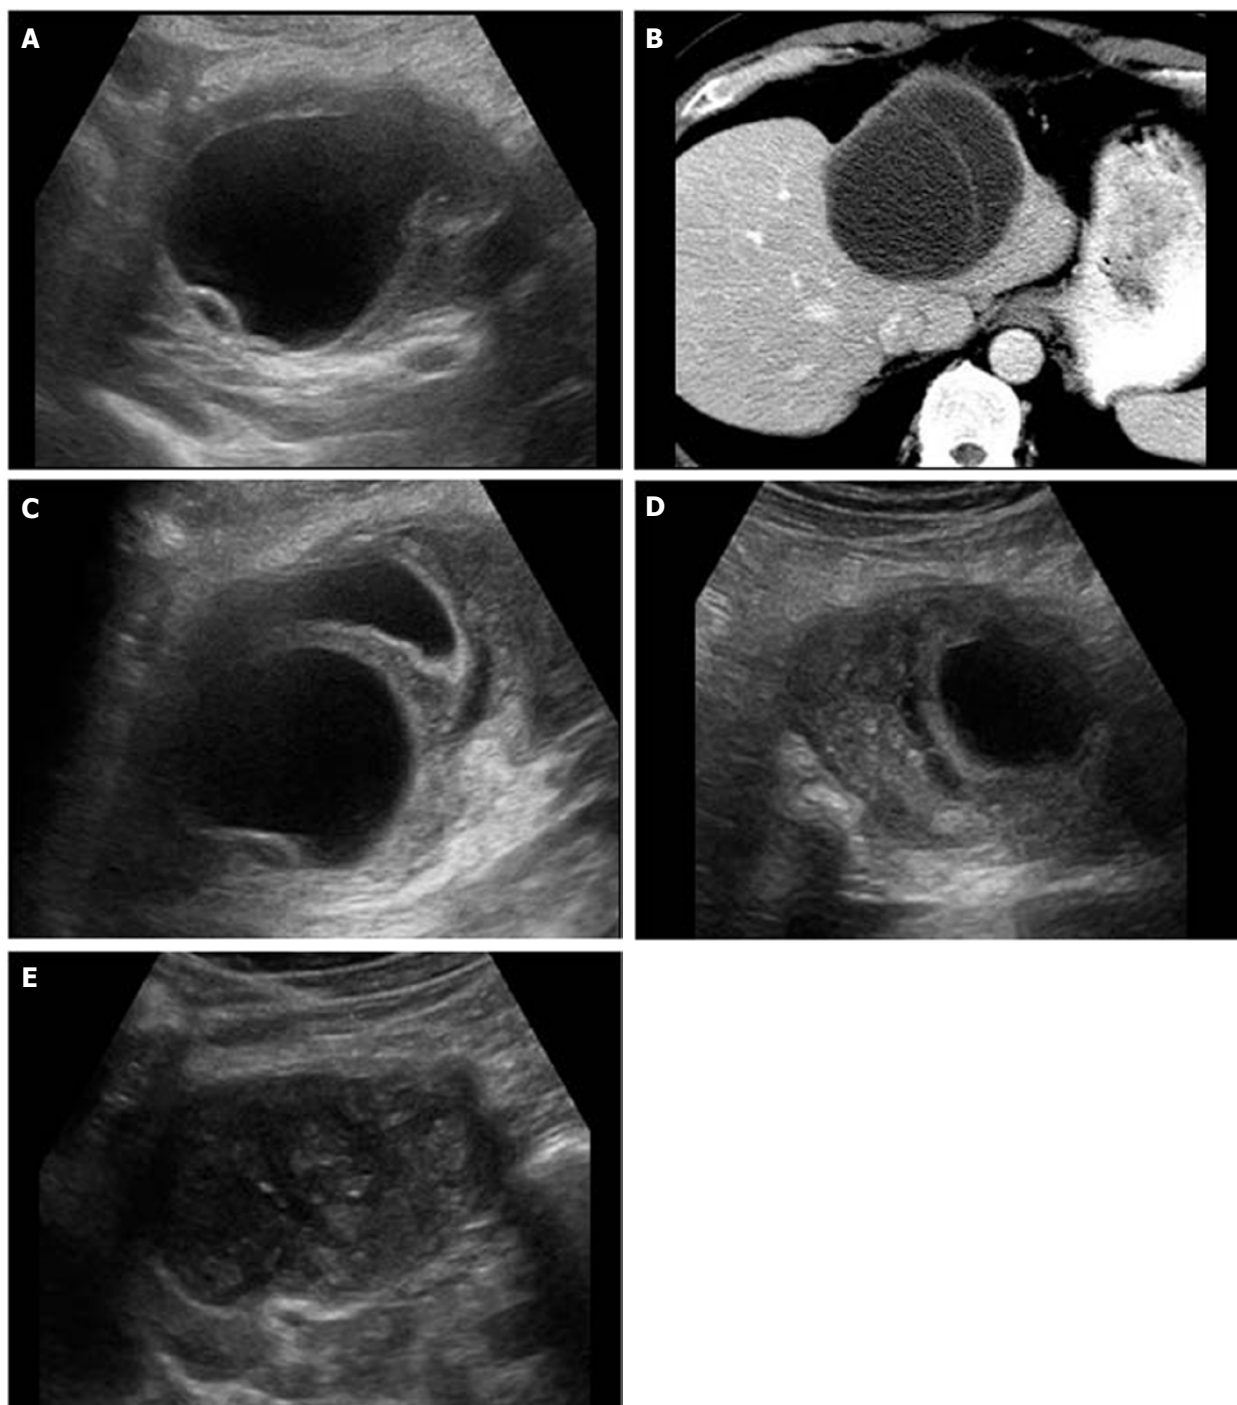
Type 1 hydatid cyst follow-up examinations conducted one to 1-18 mo after the procedure. A: US image prior to the procedure; B: CT image prior to the procedure; C: US image 6 mo after the procedure, wall thickness and irregularity of the cyst is seemed to be increased; D: US image 12 mo after the procedure, cyst dimension and tension is seemed to be markedly decreased and the contents can could be seen to have solidified; E: US image 18 mo after percutaneous drainage. Cyst can could be seen to have completely collapsed and solidified in the image and a pseudotumor image is formed. US: Ultrasound; CT: Computerized tomography.
